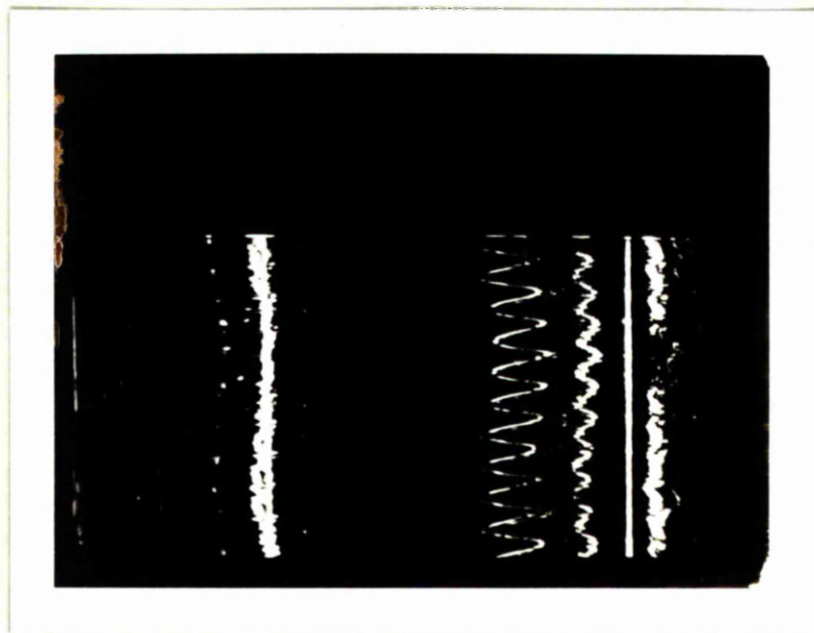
Ultrasonic TP-scan showing movement
